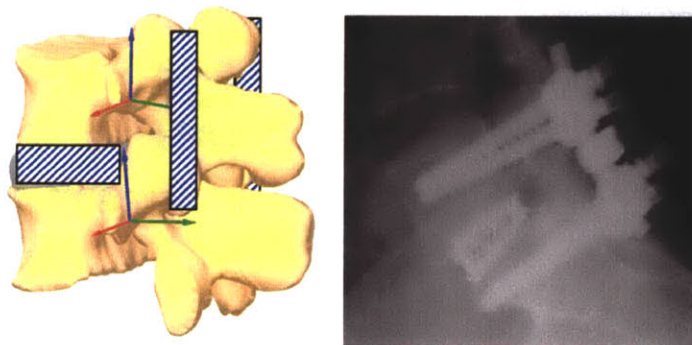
Idea of spinal fusion and anterior and posterior fusion on X-ray.
